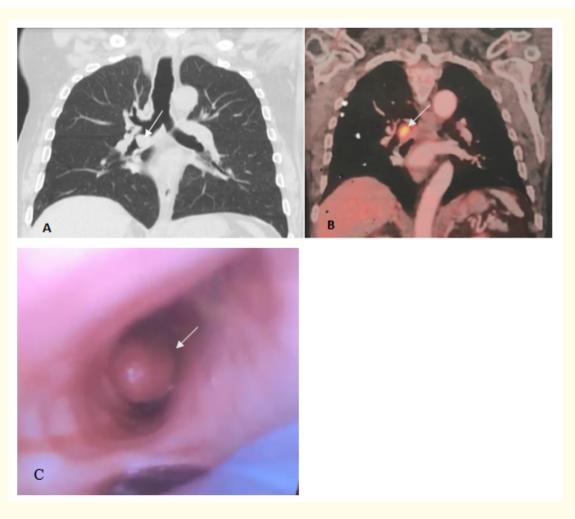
A- Computed tomography (CT) revealed an endobronchial lesion of 25 mm x 10 mm located at the bronchus intermedius (white arrow). B- Positron emission tomography showing the same lesion with hypermetabolic behaviour, maximum standardized uptake value (SUVmax) of 6,5 (white arrow). C- Video fibreoptic image of the endobronchial tumor (white arrow).
